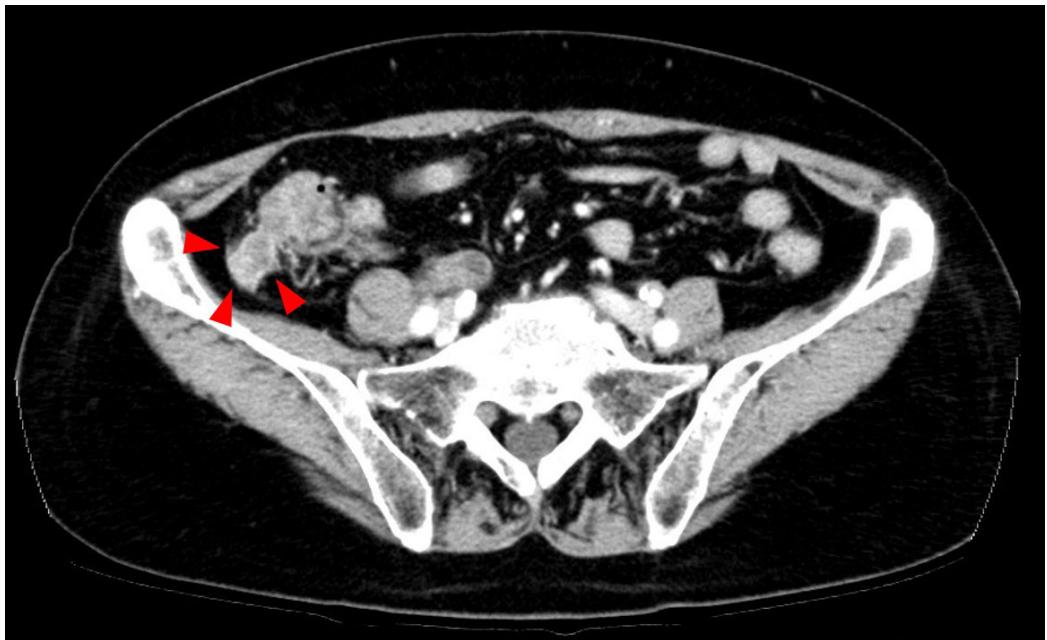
Abdominal computed tomography. An enhancing heterogeneous mass was found at the right paracolic gutter (Arrow heads).
